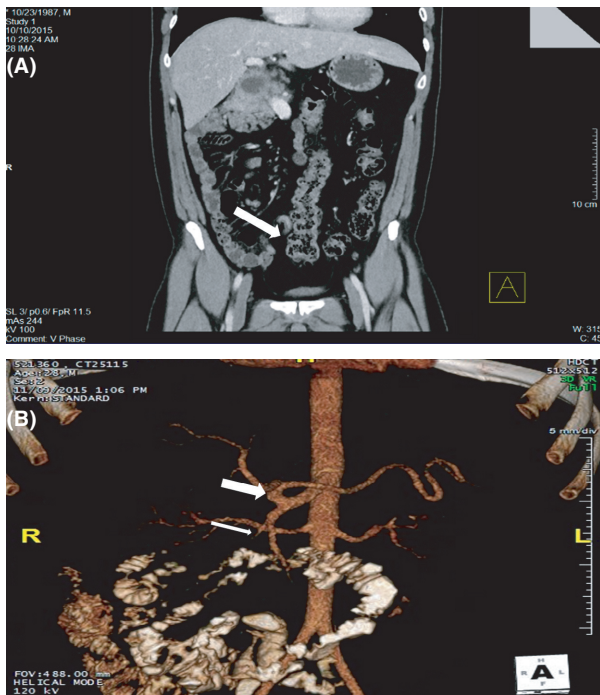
(A) Coronal cut from the abdomino-pelvic CT scan, showing bowels malrotation and an inferiorly located hepatic flexure (white arrow). (B) 3D reconstruction of the scan performed with IV contrast showing the vascular variation where the SMA branches from the celiac trunk (thick white arrow), giving off the gastroduodenal artery (thin white arrow).
